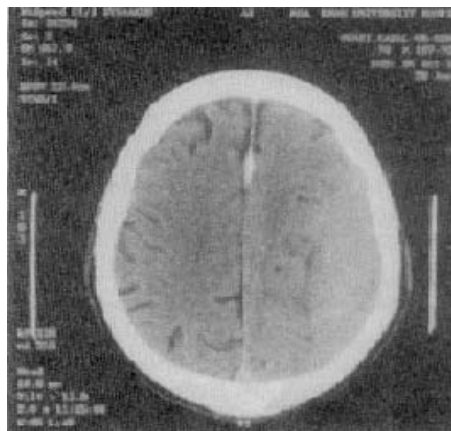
CT scan of patient showing the classical double convex appearance of an extradural hematoma.
